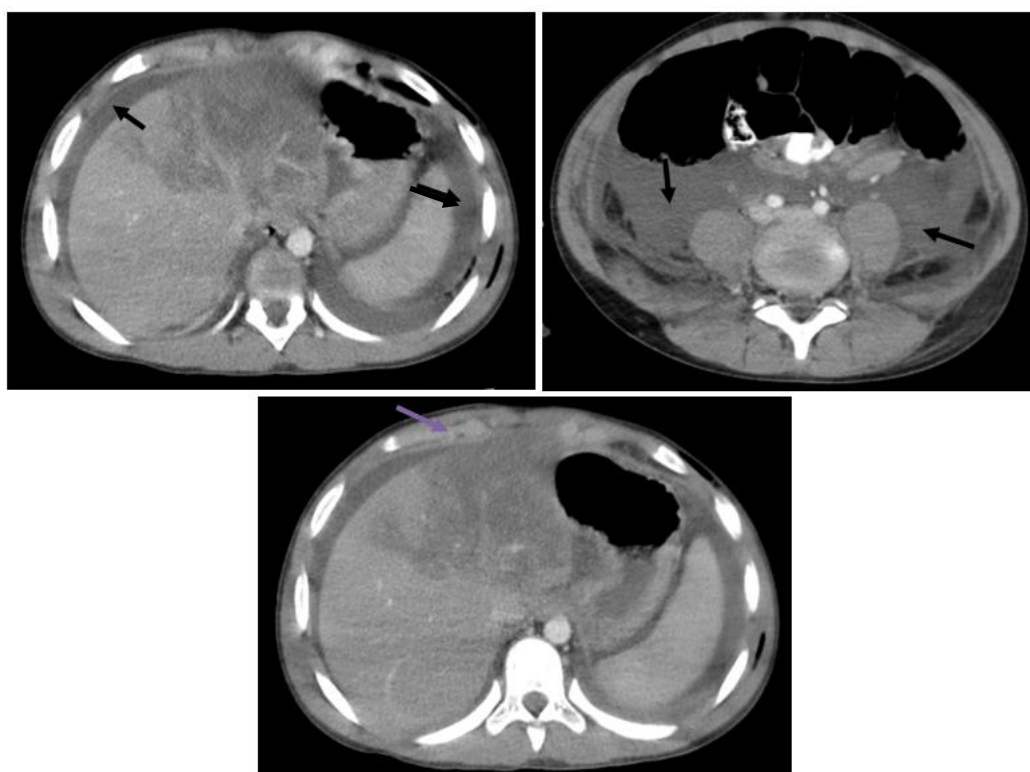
Angio CT of the same patient showing: (A and B) Large amount of intraperitoneal effusion filling all cavities (black arrow). (C): Area of hypodensity related to perfusion abnormalities (purple arrow)
